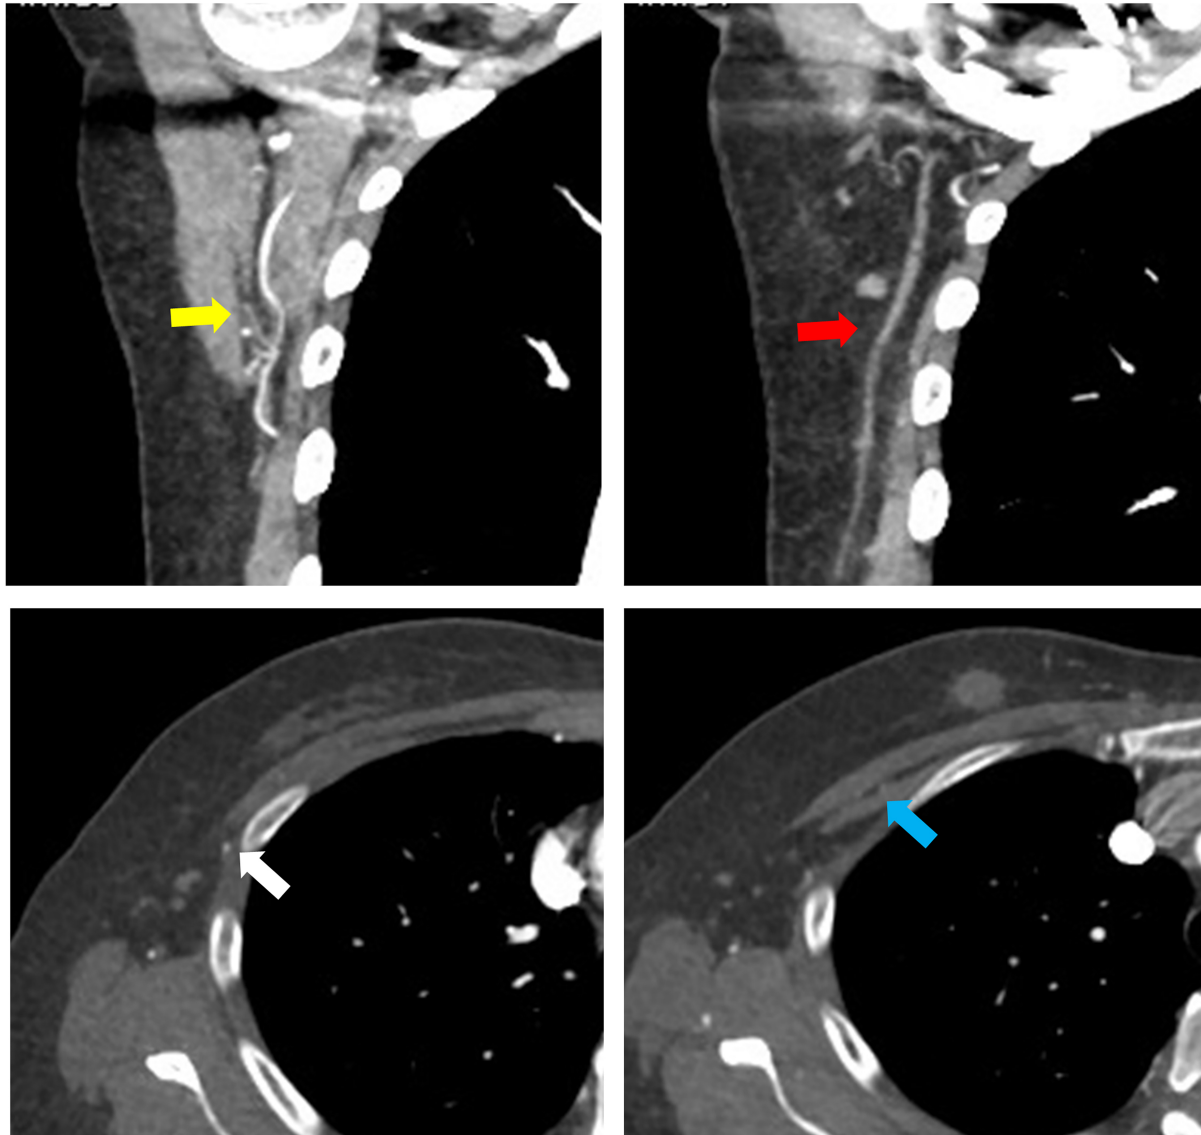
The yellow arrow indicates the subscapular vascular tree, the red arrow points to the lateral thoracic artery, the white arrow highlights the lateral thoracic vein, and the blue arrow shows the thoracoacromial vessels, all of which can be evaluated preoperatively using CTA. CTA: Computed tomography angiography.
